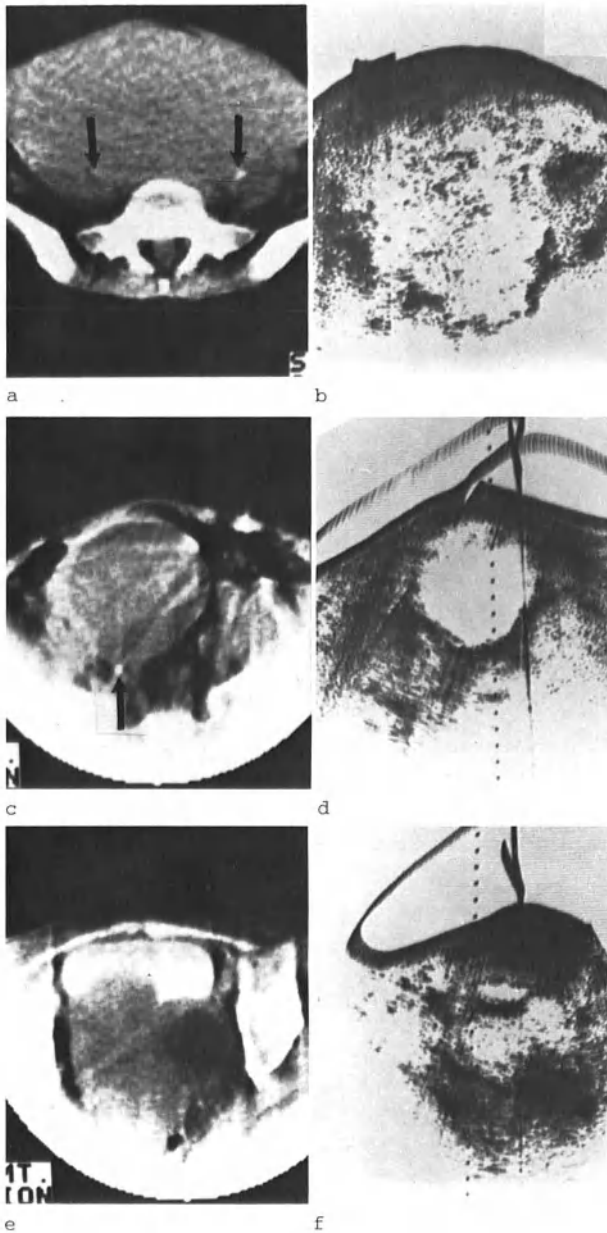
Ureters. (a) Large uterine leiomyoma is demonstrated to displace but not involve both ureters (*arrows*). (b) Ultrasound at same level reveals more about internal architecture of mass but does not demonstrate ureters. (c) C.A.T. section 9 cm cephalad to the symphysis in a patient with extensive endometriosis, reveals that right ureter (*arrow*) has been incorporated in the wall of a large cystic mass. (d) Ultrasound of cyst. (e) C.A.T. 3 cm above the symphysis demonstrates a smaller cyst as well as a soft tissue mass engulfing uterus and impressing bladder. (f) Ultrasound at this level shows both cystic and solid components but does not suggest the extensiveness of the abnormality quite as fully
